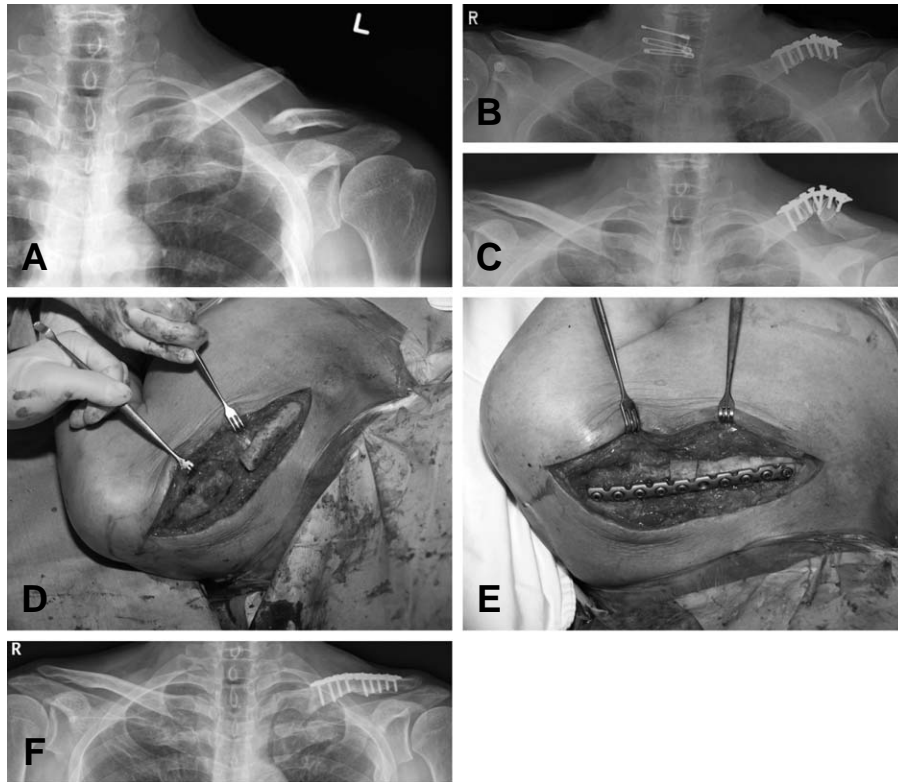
A 65 year old male patient with a case of nonunion (A) A preoperative radiograph showing a severely displaced midshaft clavicle fracture (B) Immediate postoperative radiograph (previous treatment from other hospital) (C) Postoperative radiograph at 3 months, showing implant failure (D) Photo showing removal of implant and dead bone with resulting segmental bone defect (E) Photo showing plate fixation with autogenous strut bone graft (F) Postoperative radiograph at one year, showing successful bone union.
